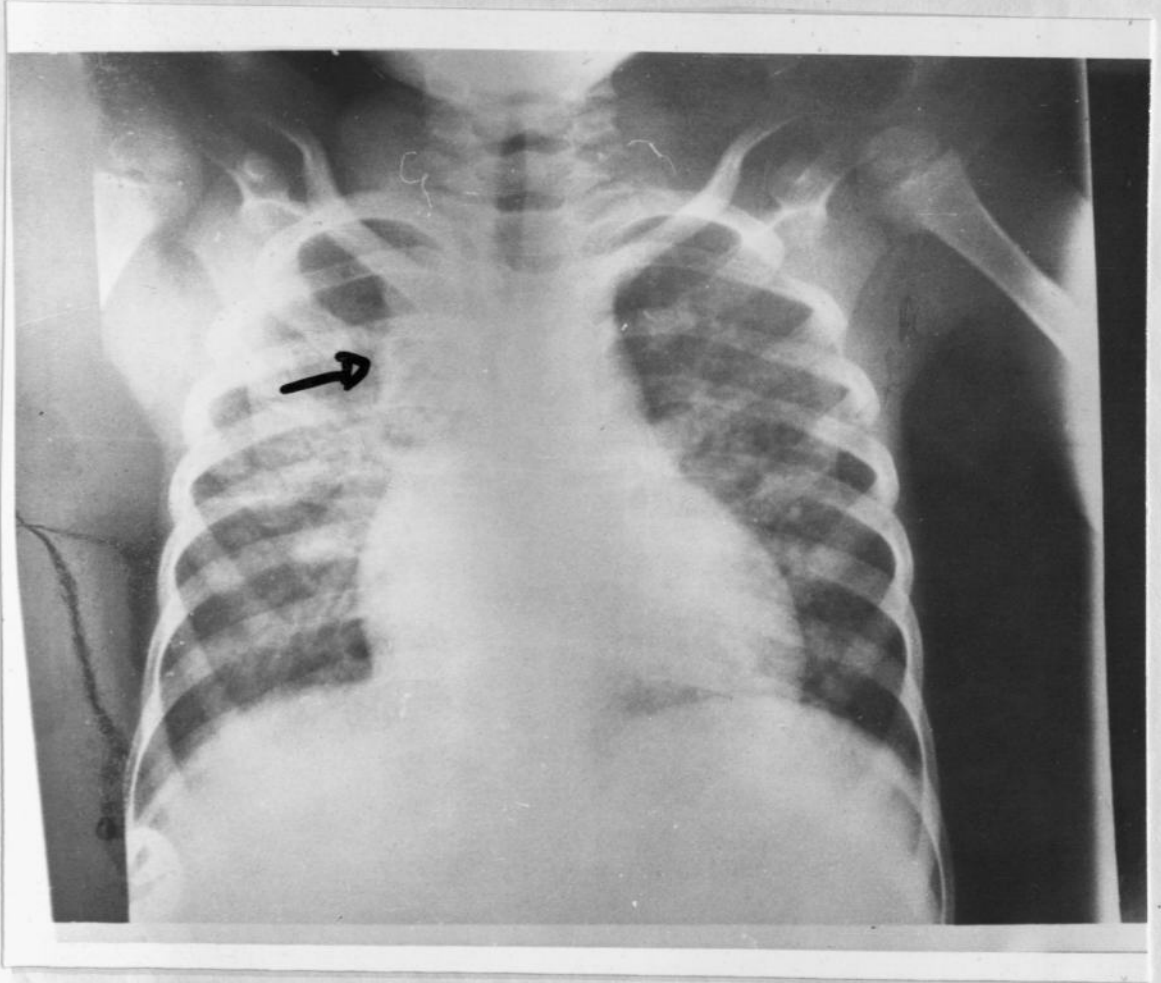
Chest radiograph in one case of AMoL showing large mediastinal nodes (arrow pointing at them) which caused the superior vena caval syndrome in the patient. Note also the enlarged lymph nodes in the cervical region.
